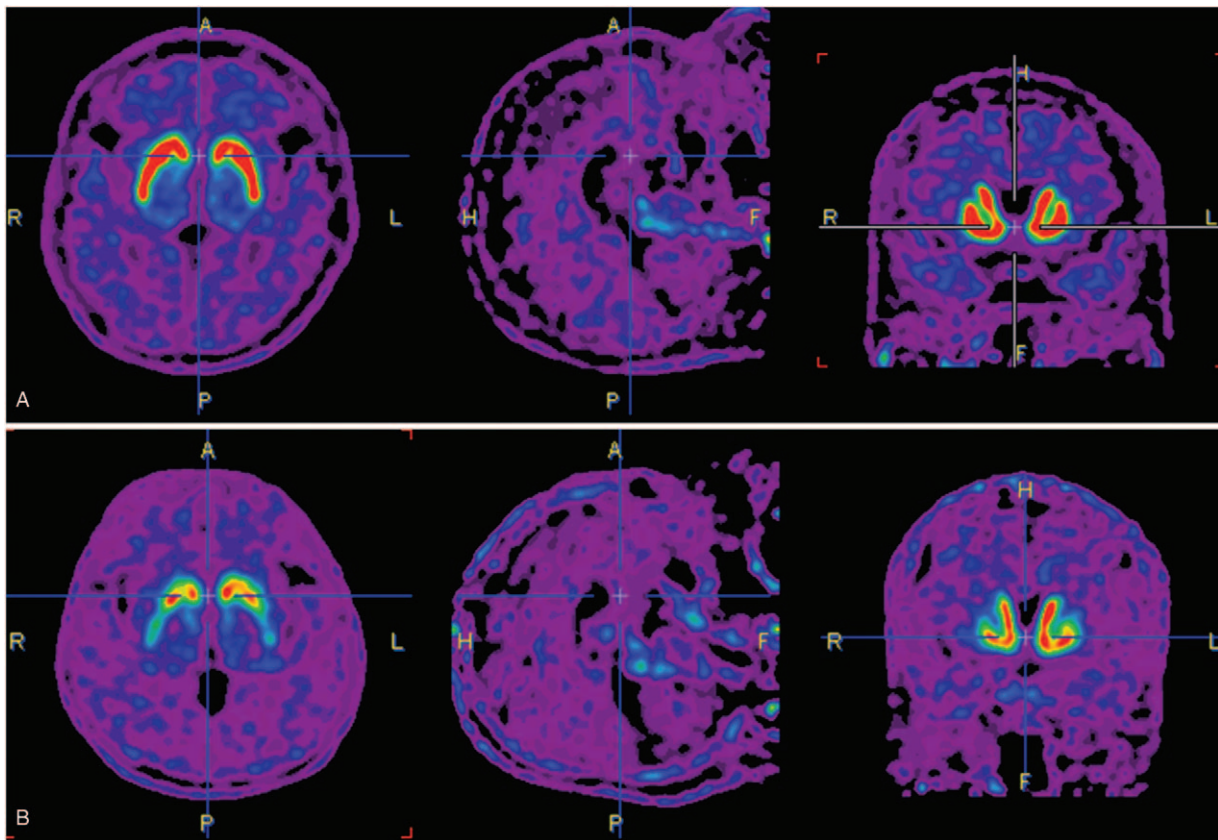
(A) Representative F-18 FP-CIT PET images in normal control and Parkinson’s disease (PD). (B) SUV of F-18 FP-CIT PET image with PD is almost absent in both *caudate nuclei* and *putamina*.
